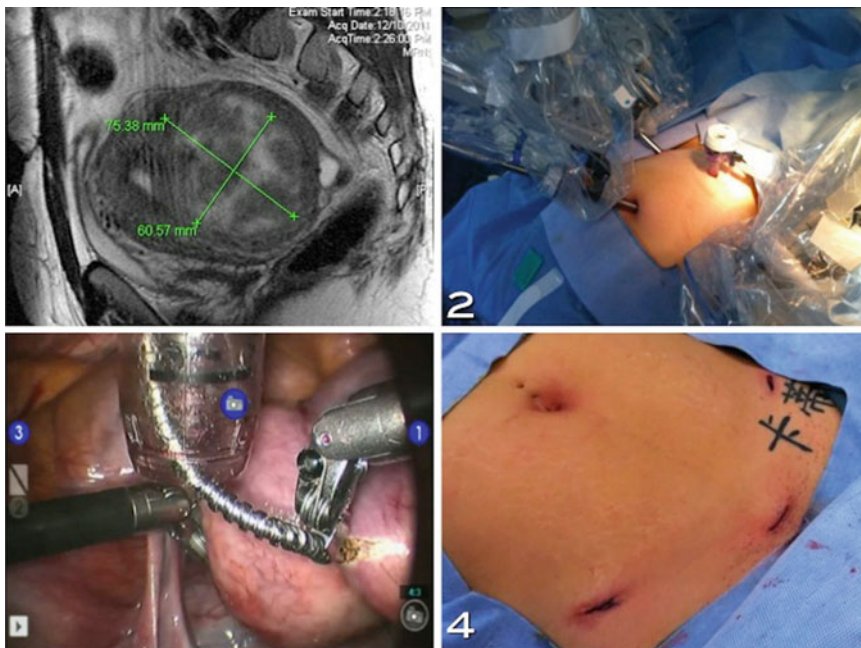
Cosmetic robotic myomectomy. (1) MRI image (T2-weighted sagittal projection) of typical surgical candidates for cosmetic RM variant at our center. Myomas in the 1–8 cm range are effectively enucleated with this technique in our experience. (2) The bedside assistant has
